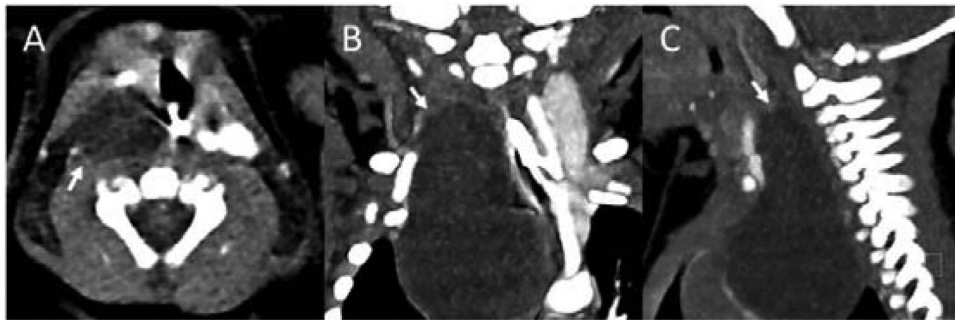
Axial (A), coronal (B), and sagittal (C) CT images in soft tissue window of a child with cervical extension of a bronchogenic cyst. The images show a well-defined cystic structure (A-C) in the sternal notch region (C). The predominant volume of the cystic structure is found in the upper thoracic region (B, C) and therefore the cervical part of the lesion presumably represents cervical extension of a thoracic bronchogenic cyst.
